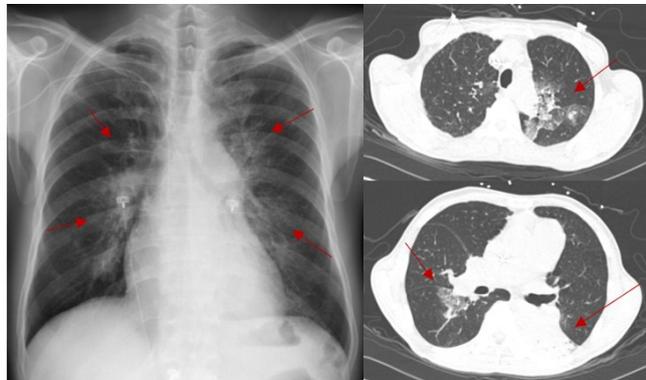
Chest X-ray and computed tomography(CT). Chest X-ray showed Increased hilar pulmonary vascular markings. Chest CT showed multifocal patchy areas of ground glass opacity on both lung and total atelectasis of left lower lobe(red arrows).
